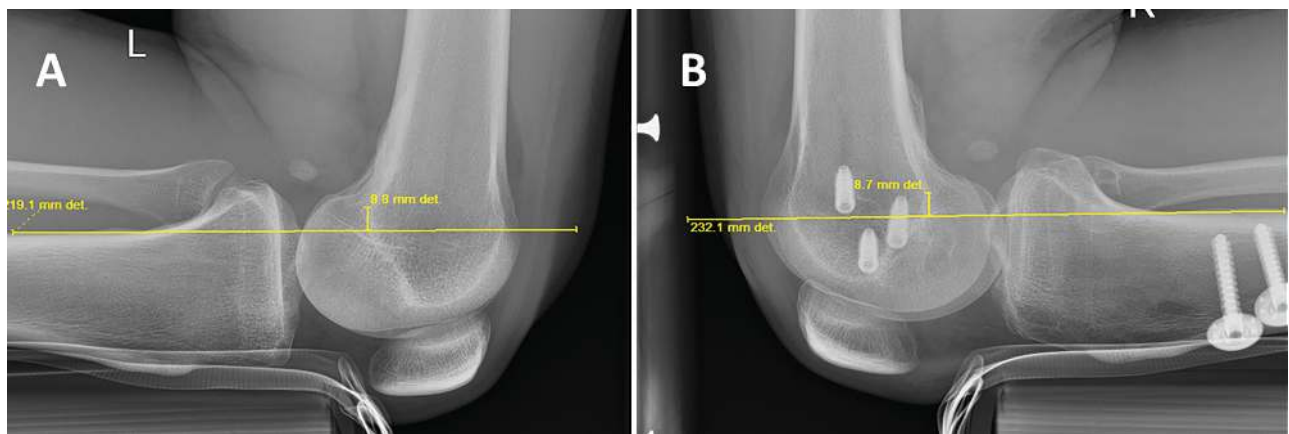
Postoperative kneeling stress radiographs showing restoration of posterior knee stability at 2-year follow-up after DB PCLR. (A) Uninjured left knee demonstrating posterior tibial translation of 8.8 mm. (B) Injured right knee displaying 8.7 mm of posterior tibial translation, indicating a side-to-side difference of 0.1 mm after DB PCLR at 2-year follow-up. DB PCLR, double-bundle posterior cruciate ligament reconstruction.
